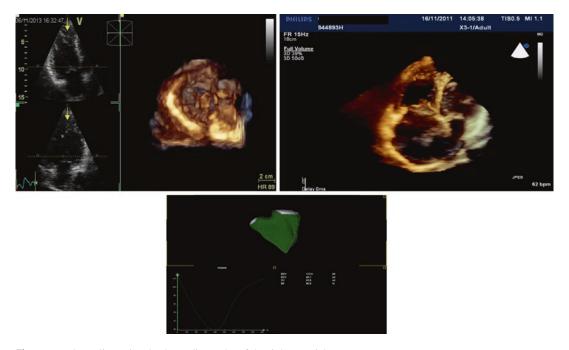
Three-dimensional echocardiography of the right ventricle
